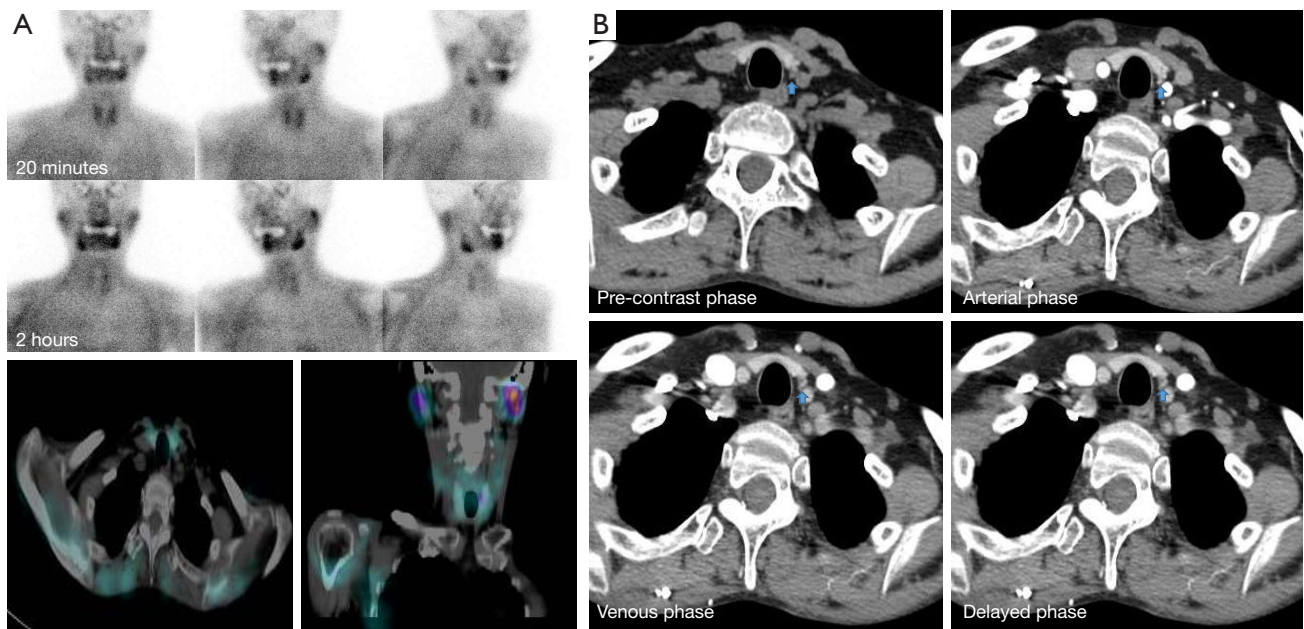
A representative case where localization failed using ^{99m}Tc -sestamibi SPECT (A), yet effectively identified by 4D CT (B). Images of a 58-year-old woman with a left inferior parathyroid lesion. (A) ^{99m}Tc -sestamibi SPECT does not show abnormal findings and is considered normal. (B) On 4D CT, a parathyroid lesion (arrow) was observed with type B enhancement characteristics. The attenuation of the lesion was lower than that of the adjacent thyroid gland during the pre-contrast phase. The arterial phase image demonstrates that the lesion has a similar attenuation as the adjacent thyroid gland, and the lesion shows a faster washout of contrast material than the adjacent thyroid gland during the delayed phase. 4D CT, four-dimensional computed tomography; ^{99m}Tc -sestamibi SPECT, technetium-99m-sestamibi single-photon emission computed tomography.
